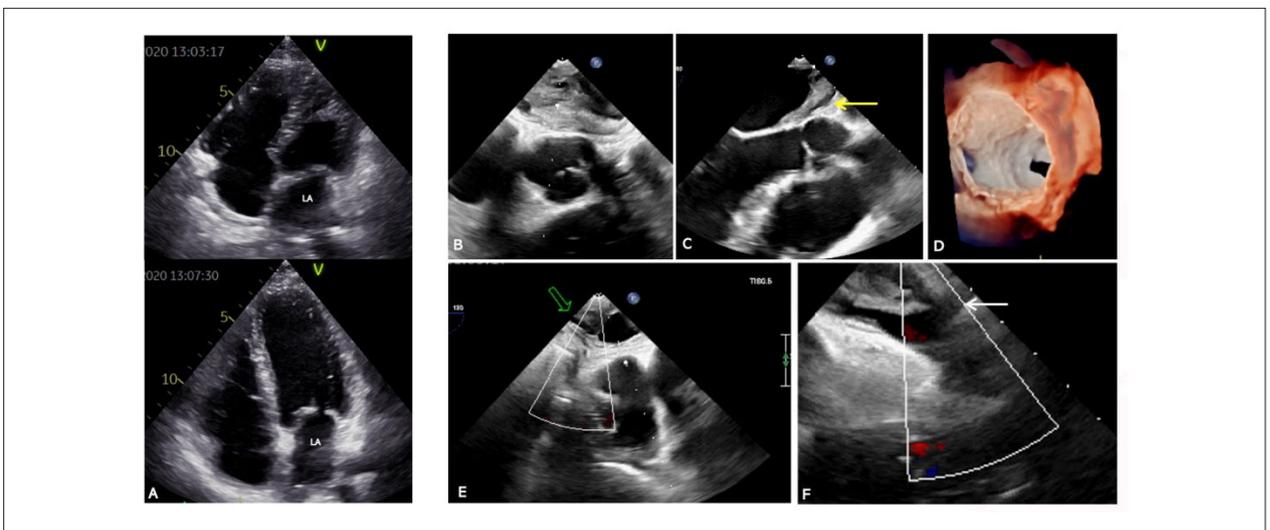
A) Transthoracic echocardiographic study showing a dense and irregular thickened ceiling mass of the LA near the right pulmonary veins ostia; B – D) Transesophageal echocardiogram showing an isoecogenic mass extending from the posterior wall of the aortic root towards the posterior left atrial wall; anteriorly there is a cleavage plane between the mass and left atrial wall (yellow arrow); posteriorly this is not the case as the limits of the mass are not clearly identified. E - F) Transesophageal echocardiogram showing LA mass related to the right pulmonary veins (right inferior pulmonary vein (RIPV) and right upper pulmonary vein (RUPV)). E) RIPV outflow compression as showed by ostial molding (green arrow). F) No interference with the RUPV outflow (white arrow). LA: left atrium.
